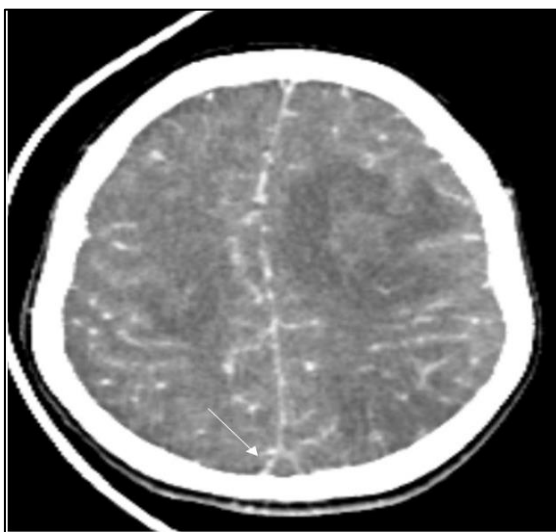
C+ brain CT in axial section: opacification defect of the superior longitudinal sinus, with intense enhancement of its wall, realizing the "Delta" or "empty triangle" sign (arrow)
